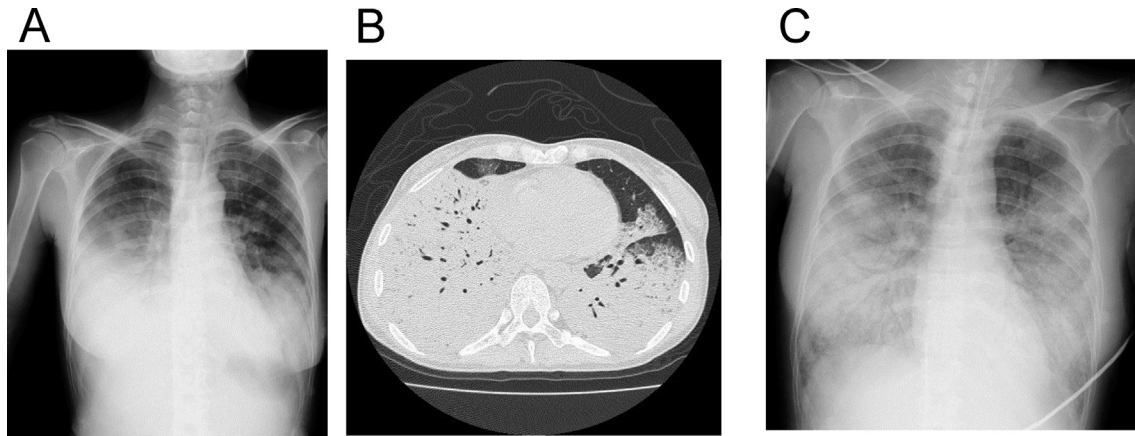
X-ray radiography of the patient on Day5 (A) and Day 8 (C) of onset. Computed tomography of the patient on Day 5 of onset (B).
